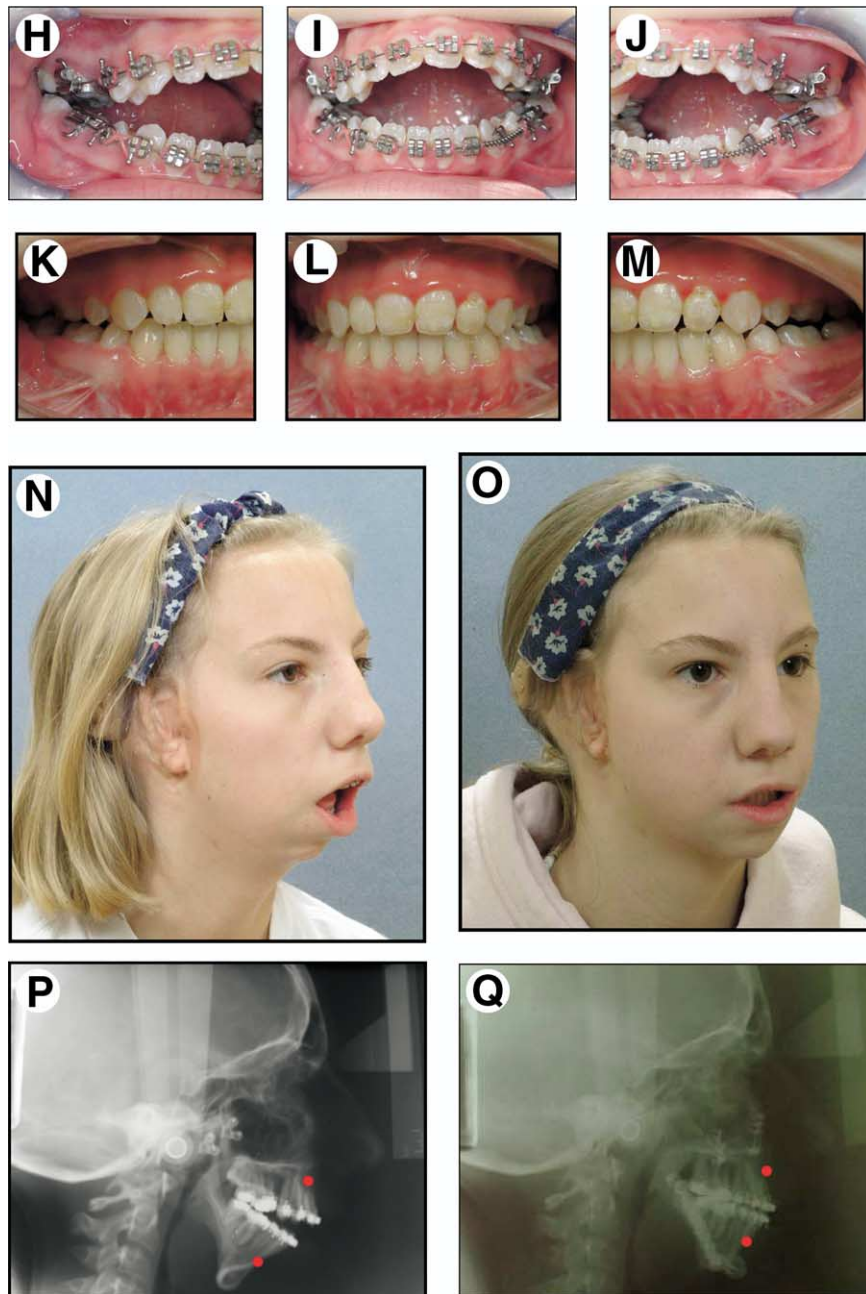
(cont'd). H-M, Occlusal views before and after reconstruction. N, O, Oblique facial views before and after reconstruction. P, Q, Lateral cephalometric radiograph views before and after reconstruction.
